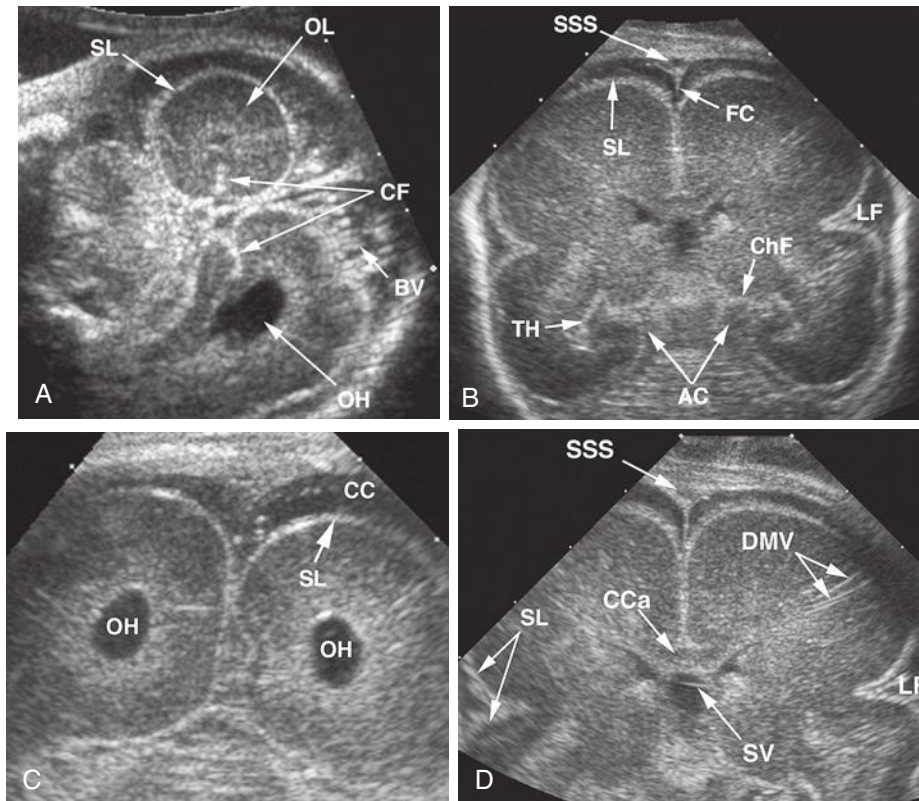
A through D, Sequence of sonograms obtained through fontanelles and sutures. This technique enables one to see symmetric brain anatomy. The surface leptomeninges (SL) are crucial to discriminating the edge of the brain tissue and the adjacent cisterns. AC, ambient cistern; BV, bridging veins; CC, convexity cistern; CCa, corpus callosum; CF, calcarine fissure; ChF, choroidal fissure; DMV, deep medullary veins; FC, falx cerebri; LF, lateral fissure; OH, occipital horn; OL, occipital lobe; SSS, superior sagittal sinus; SV, septal vein; TH, temporal horn.
